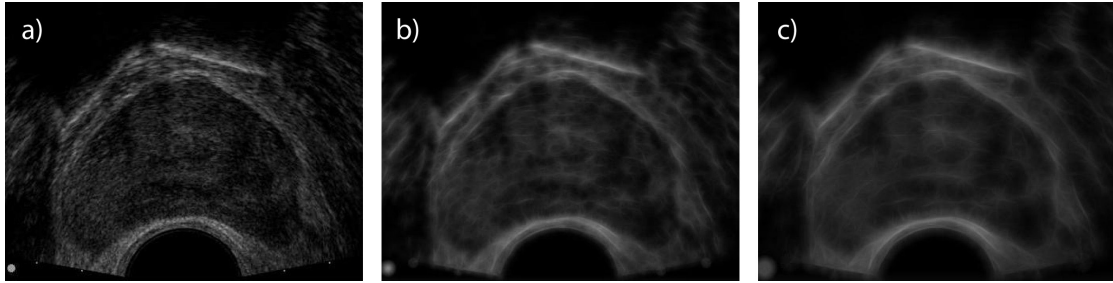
Stick Filter applied to ultrasound image, in plane
